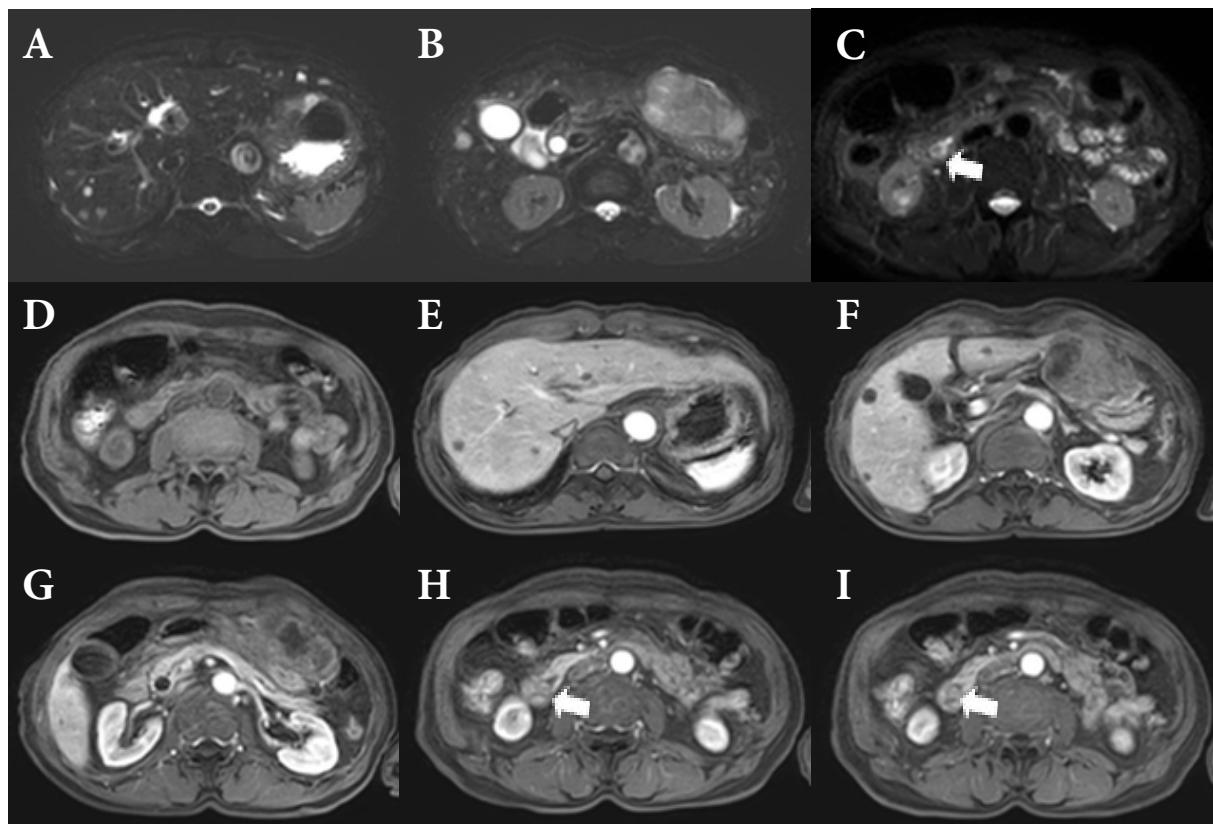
Magnetic Resonance Imaging (MRI) with a hepatocyte specific contrast agent. Axial T2-weighted fat-suppressed fast spin-echo images (A-C) showing moderate dilation of extra- and intrahepatic bile ducts with an oval-shaped intra-luminal filling defect (arrow). Pre (D) and arterial-phase post-contrast axial T1w-3Dfs SGR images (E-I) demonstrating a small smoothly well-defined mildly enhancing nodule in the distal part of a common bile duct (arrow).
